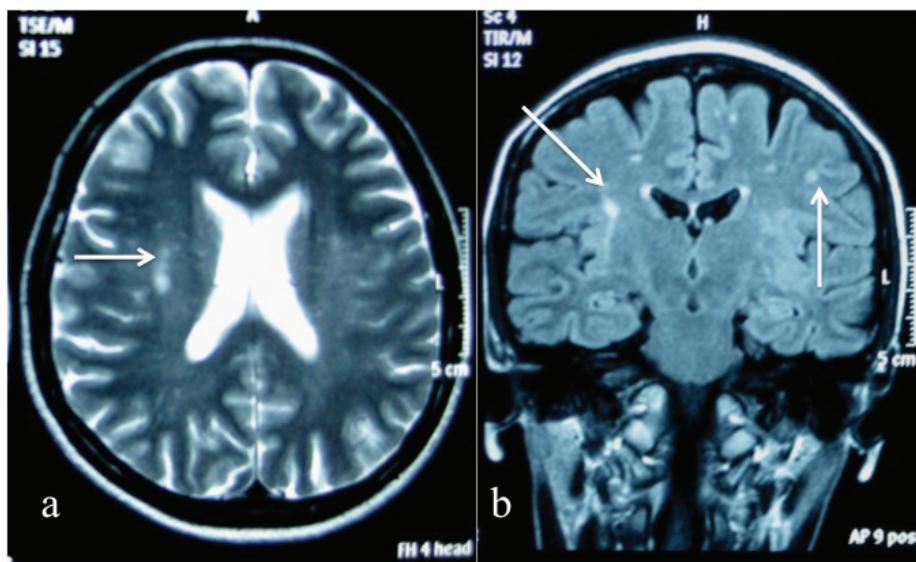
MR imaging in July 2010 after the development of brain stem sign, seizures and CSF pleocytosis from late-onset encephalitis. a) Axial T2W and b) coronal FLAIR showing increasing number of white matter hyperintensities (white arrows), some of which was slightly larger in the right corona radiata. No enhancement was demonstrated on post contrast images. Both temporal lobes appeared unremarkable.
